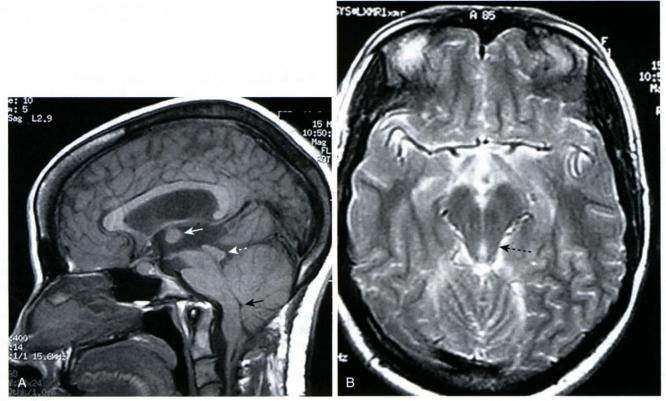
A, Sagittal T1-weighted (T1W) magnetic resonance (MR) image of an adult patient with Arnold-Chiari type II deformity. The posterior fossa is small with a widened foramen magnum. There is inferior displacement of the cerebellum and medulla with elongation of the pons and fourth ventricle (black arrow). The brain stem is kinked as it passes over the back of the odontoid. There is an enlarged massa intermedia (solid white arrow) and beaking of the tectum (dashed white arrow). B, Axial T2W MR image showing the small posterior fossa with beaking of the tectum (dashed black arrow). (From Waldman SD, Campbell RSD: Arnold-Chiari malformation type II. In Imaging of Pain. Philadelphia, Saunders, 2011, pp 29-30, Fig 9.1, A and B.)
